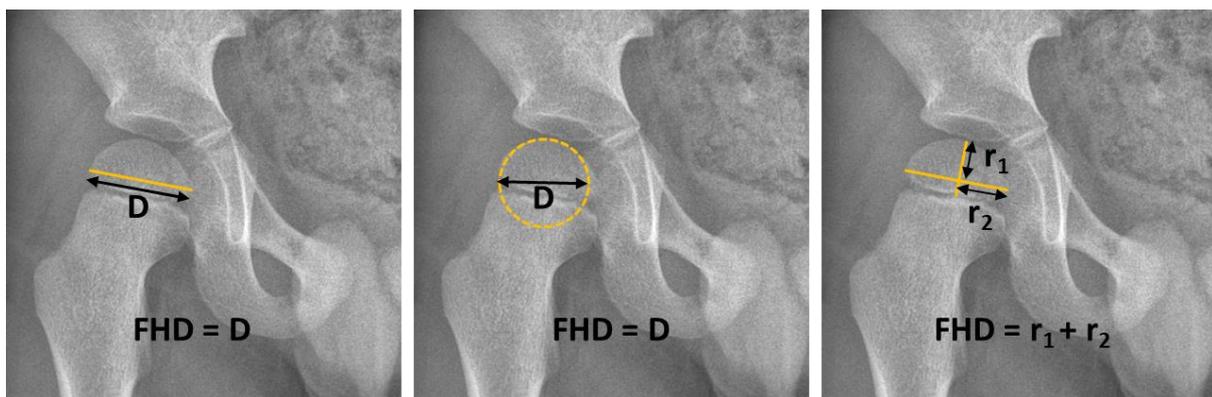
Estimates of FHD from A-P planar X-ray. (i) The maximal diameter. (ii) 'Best fit' sphere fitting to the lateral surface. (iii) The averaging method, the estimate is made from 2 perpendicular radii.
